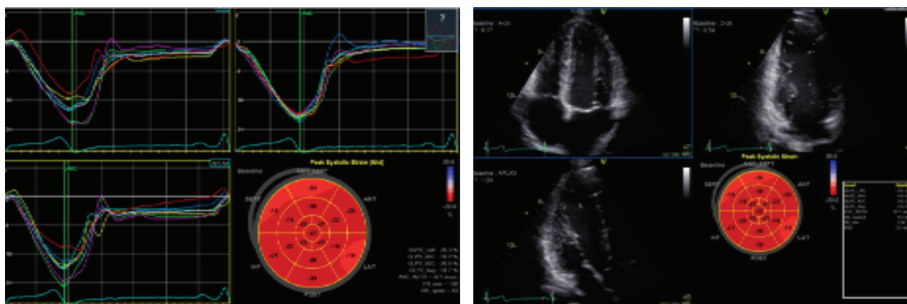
Bull's-eye map of the GLS can be displayed with strain curves or moving 2D images so each segment strain can be further evaluated at each stage of stress echocardiography.*
